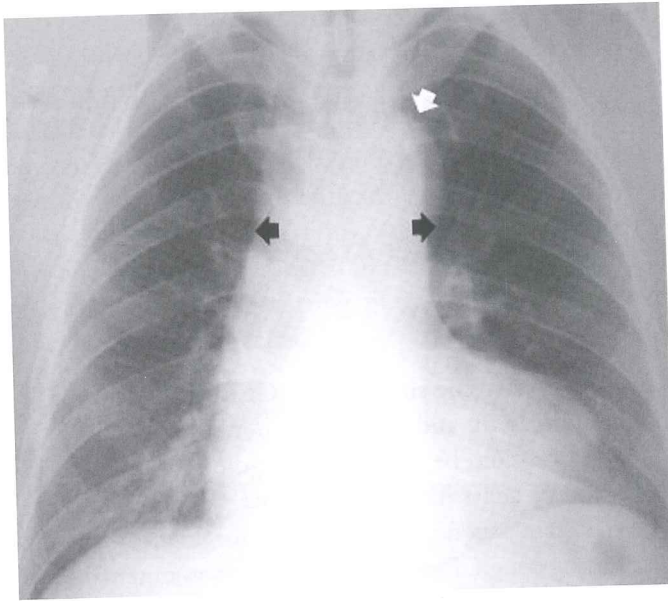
Chest X-ray shows mild mediastinal widening (black arrows) and elongation of aortic arch (white arrow).
